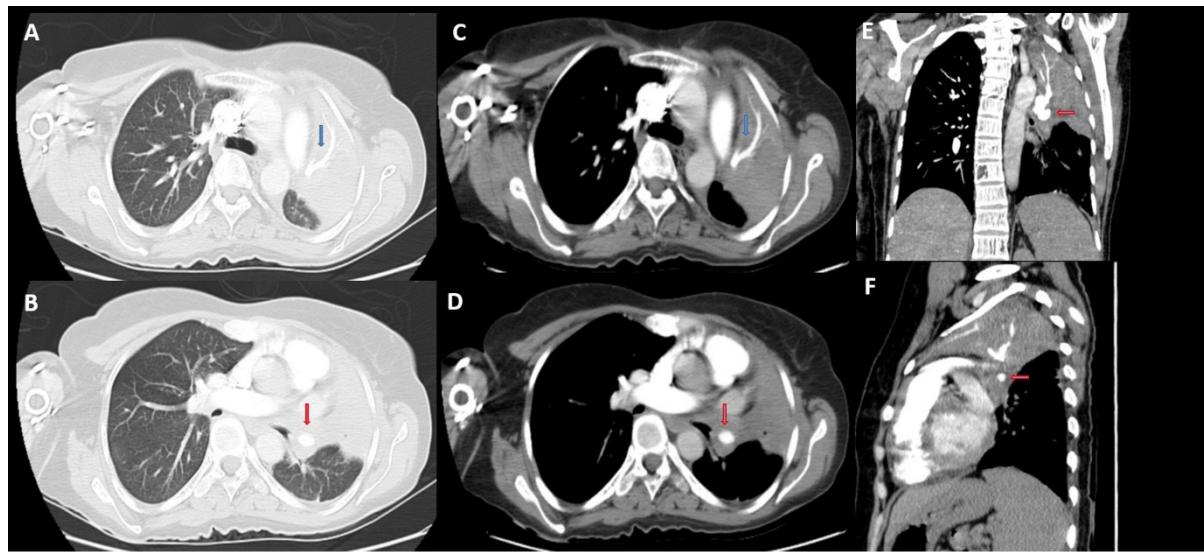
The Multidetector computed tomography angiogram
